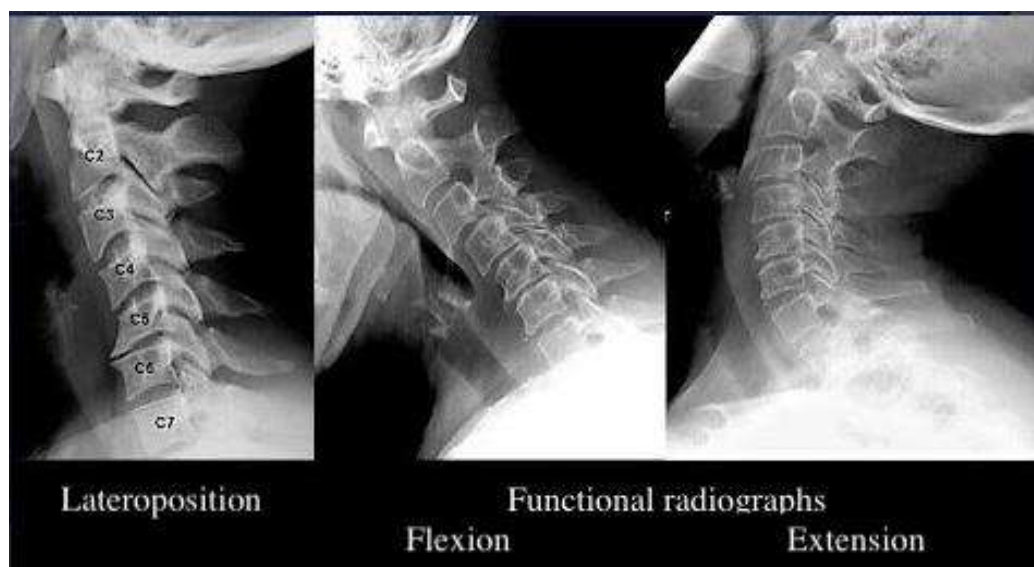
Radiograph of the cervical spine in functional positions (head flexion–extension).
